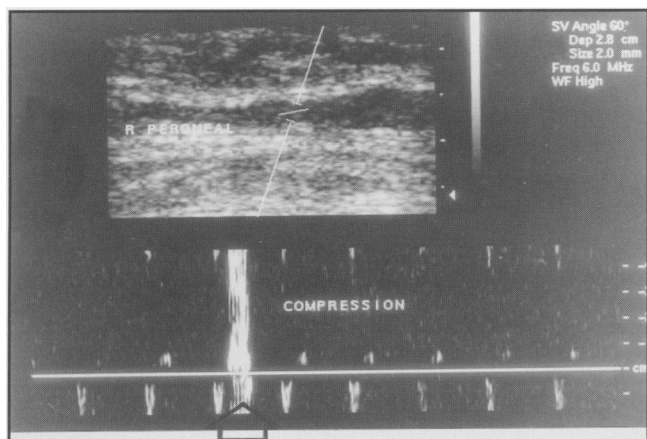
Longitudinal image depicting the peroneal vein. The doppler gate has been positioned over the vein whilst the sonographer simultaneously squeezes the patient's calf to augment blood flow within the vessel. This results in a sudden movement of the blood column of over 40 cm/sec. (Arrow).
